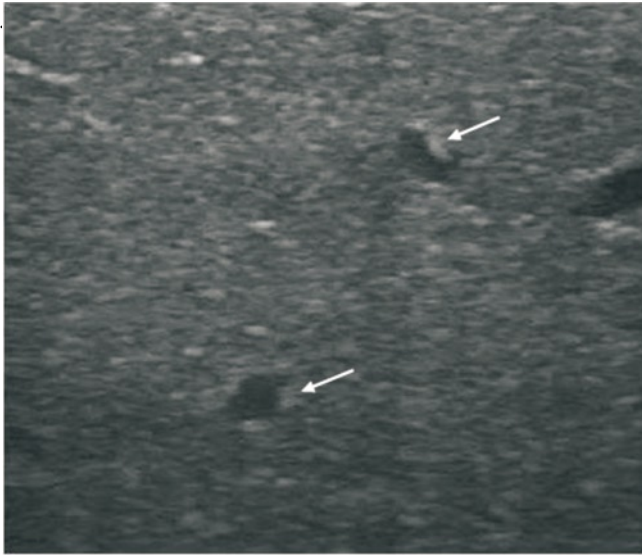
Ultrasonography of right upper quadrant of abdomen showing multiple cystic lesions with scolices (arrow) inside the cysts.
